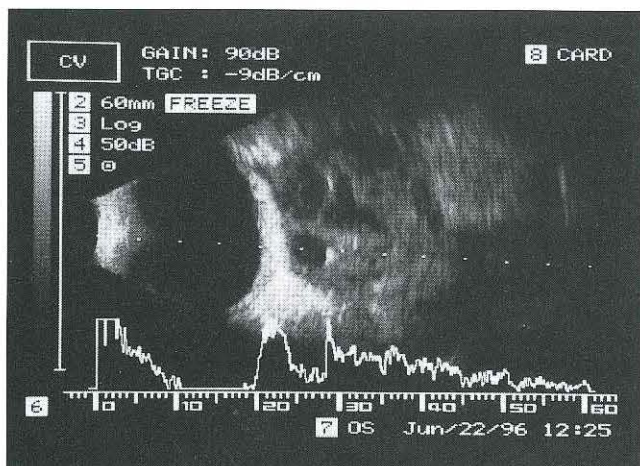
Ultrasonography of the left orbit showing a retrobulbar mass with multiple internal cystic spaces.
